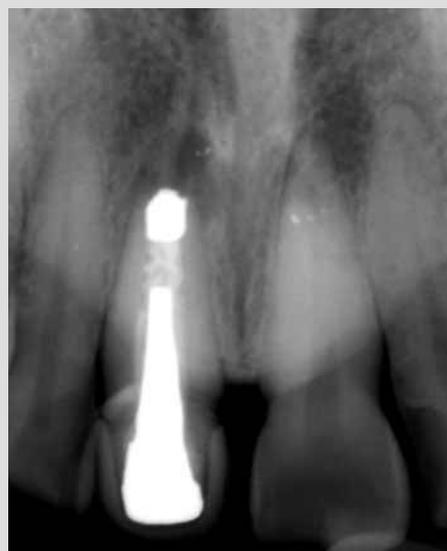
Periapical radiograph of the failing #8.
